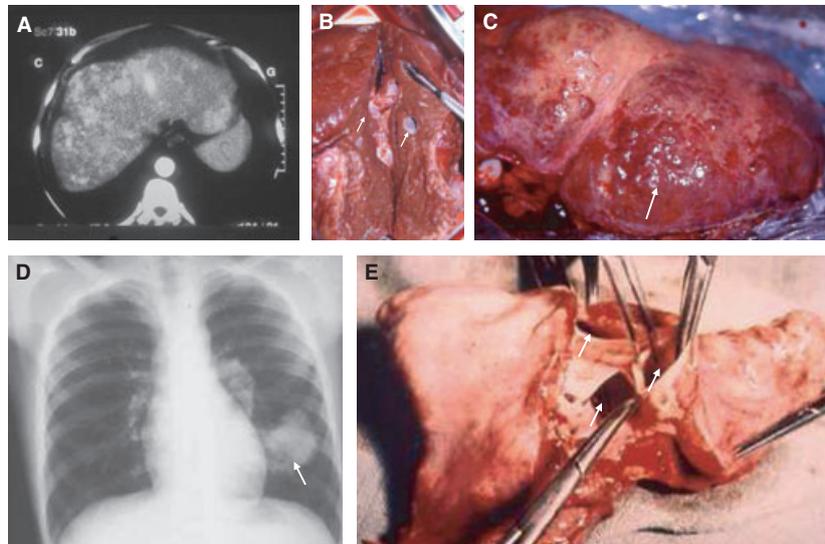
Arteriovenous malformations (AVMs) observed in hereditary hemorrhagic telangiectasia. (A) Hepatic AVMs on computed tomography scan. (B, C) Macroscopic examination showing larger and dilated vessels. (D, E) Pulmonary AVMs on (D) chest X-ray and (E) after surgery.
